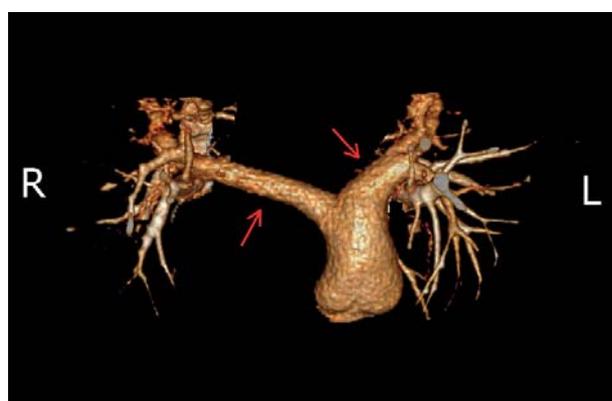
3D reconstruction obtained from the CT scan of the pulmonary trunk and large proximal branches. Narrowing of the left and right pulmonary arteries, 12 mm and 10 mm respectively (red arrows)
